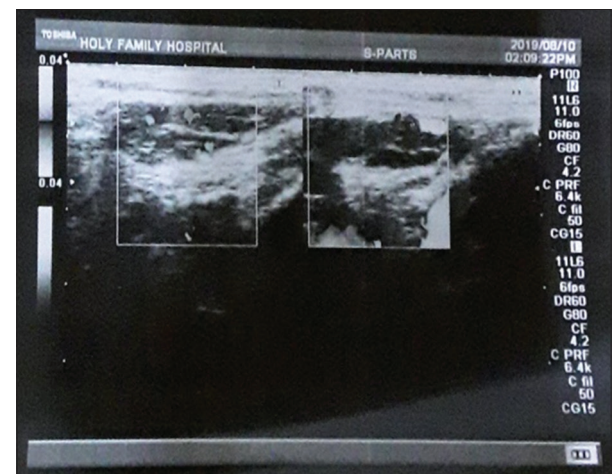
Two-dimensional grayscale sonogram of inguinal masses
